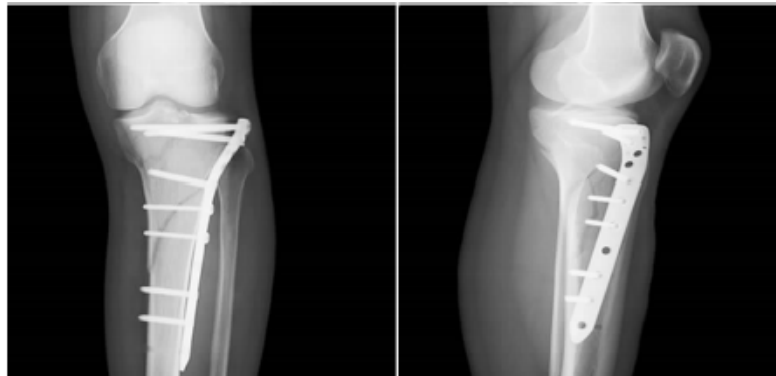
The X-ray after therapy
